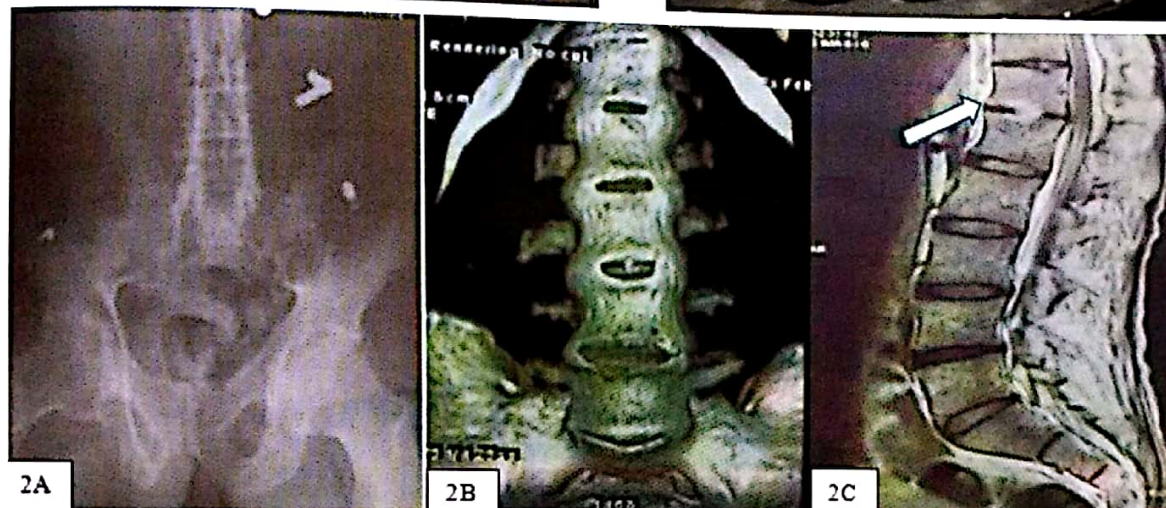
2A x-ray: bilateral sacroiliitis IV degree. 2B CT ankylosis of spine. 2C MRI acute inflammation
